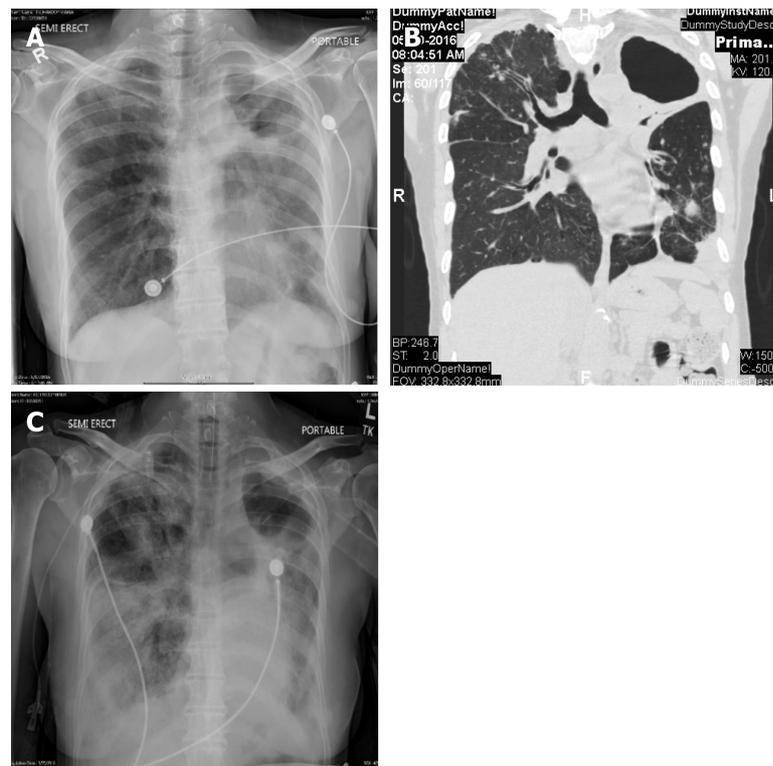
X-ray chest and computerized axial tomography (case 3). A: X-ray chest revealing the left upper lobe cavity and left lower lobe infiltrates at time of admission; B: Computerized axial tomography scan of the chest at time of admission revealing left lung thick walled cavities and multiple nodules on both side; C: X-ray chest revealing worsening of the bilaterals infiltrate after intubation and of the anti-tuberculosis medications.
